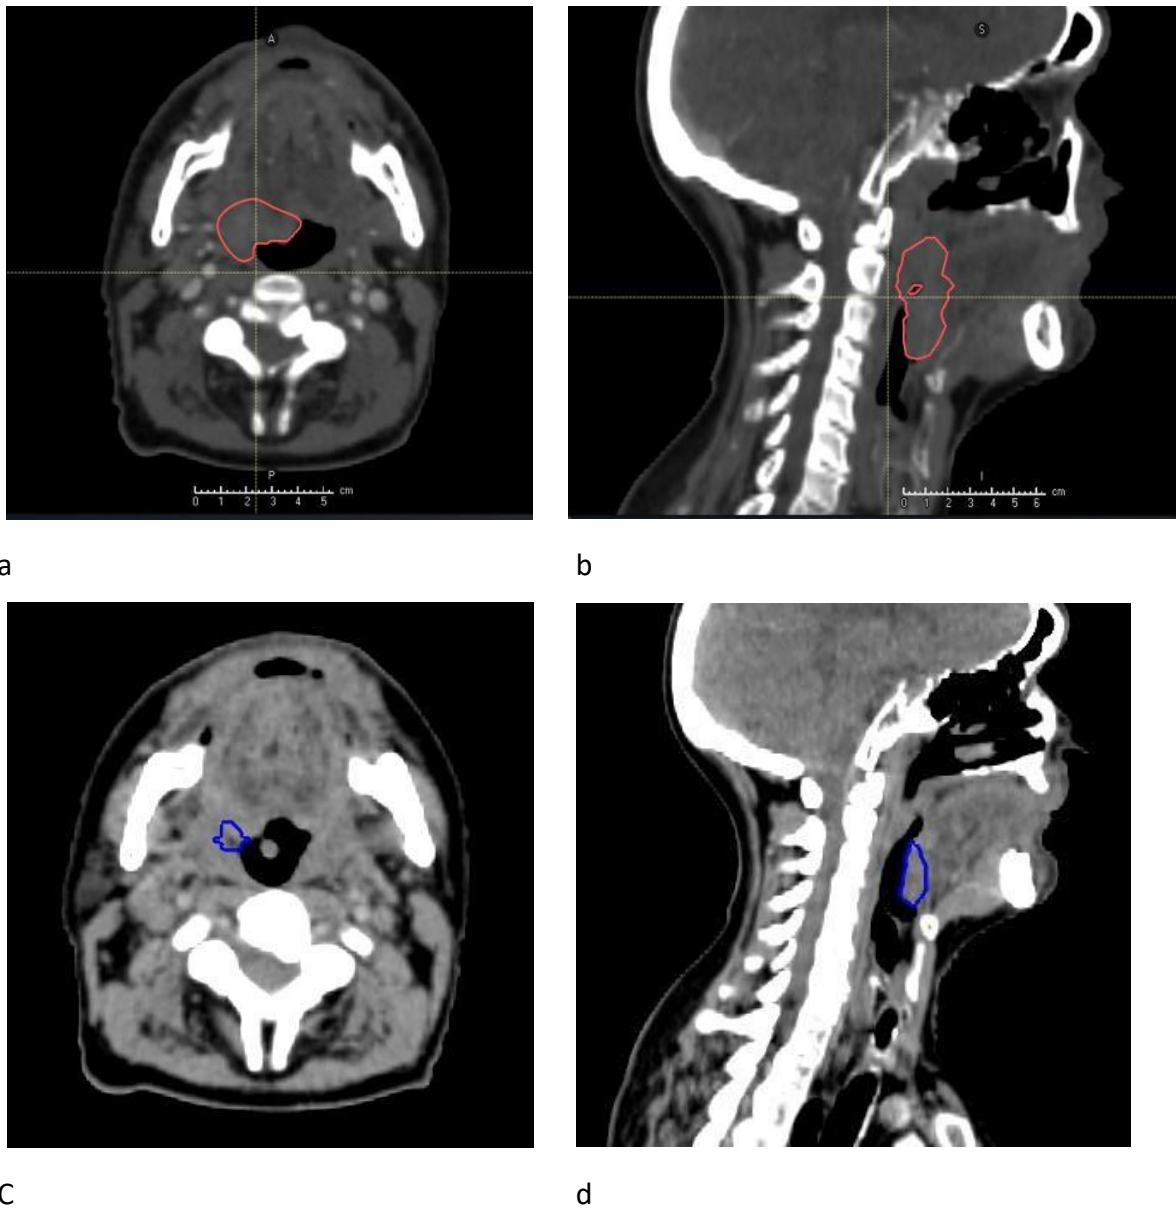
a – d Transverse and sagittal slices of prePET-CT (Fig. 3.5 a+b) and iPET-CT (Fig. 3.5 c+d) CT components for case 2. High dose GTV\_P outlined in red, bGTV\_iP in blue
